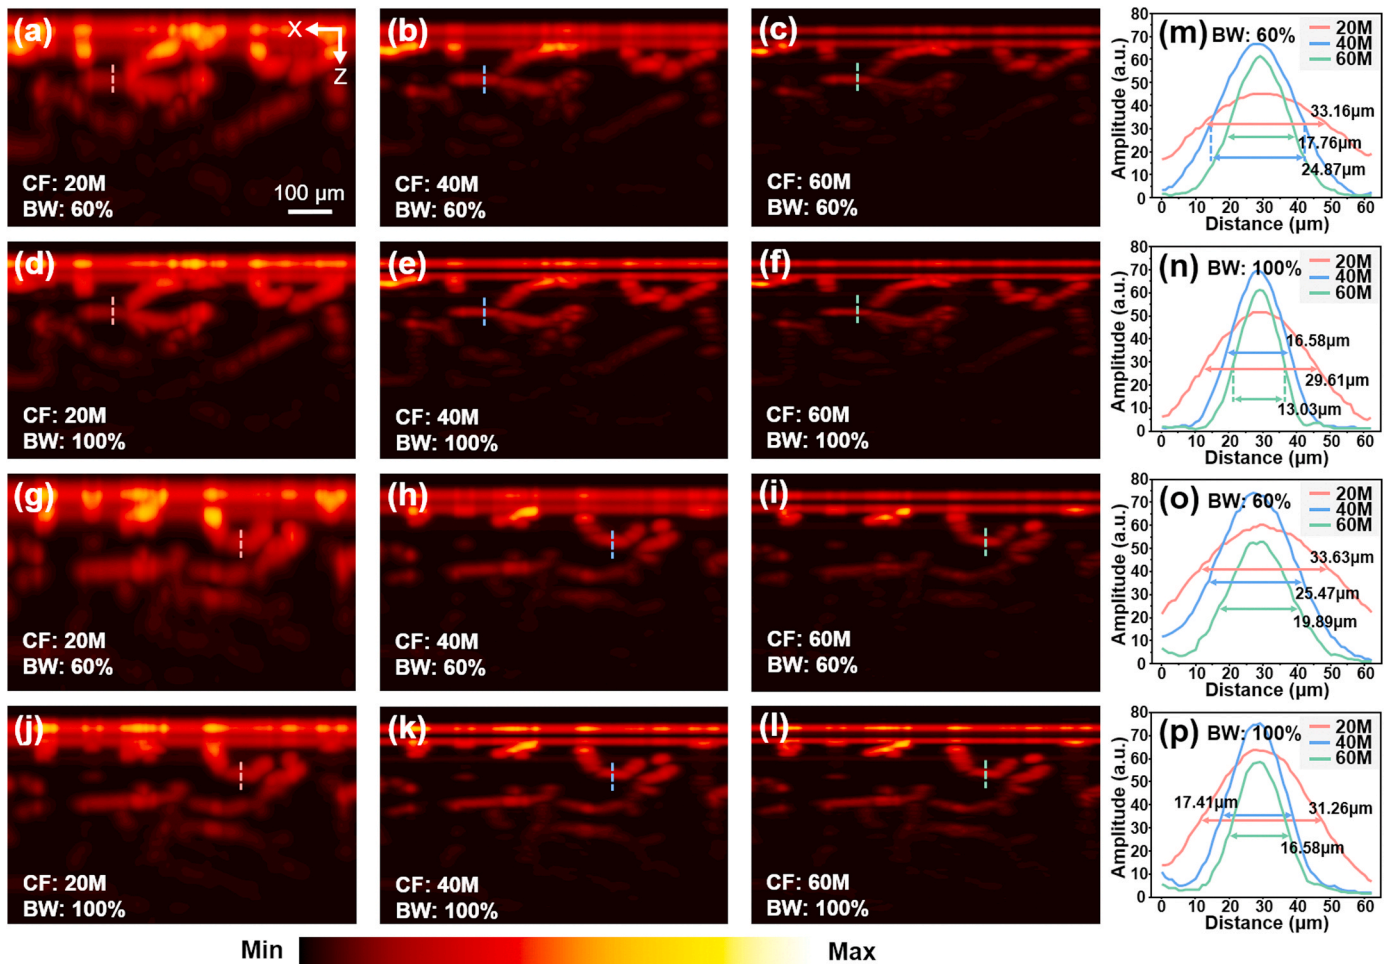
Computational imaging results of ultrasonic transducers at different center frequencies and bandwidths. (a-c) Position 1 with center frequencies of 20 MHz, 40 MHz, and 60 MHz and a bandwidth of 60%. (d-f) Position 1 with center frequencies of 20 MHz, 40 MHz, and 60 MHz and a bandwidth of 100%. (g-i) Position 2 with center frequencies of 20 MHz, 40 MHz, 60 MHz, and 60% bandwidth. (j-l) Position 2 with center frequencies of 20 MHz, 40 MHz, 60 MHz, and 100% bandwidth. (m) PA amplitude along the dashed lines in images (a-c). (n) PA amplitude along the dashed lines in images (d-f). (o) PA amplitude along the dashed lines in images (g-i). (p) PA amplitude along the dashed lines in (j-l).
